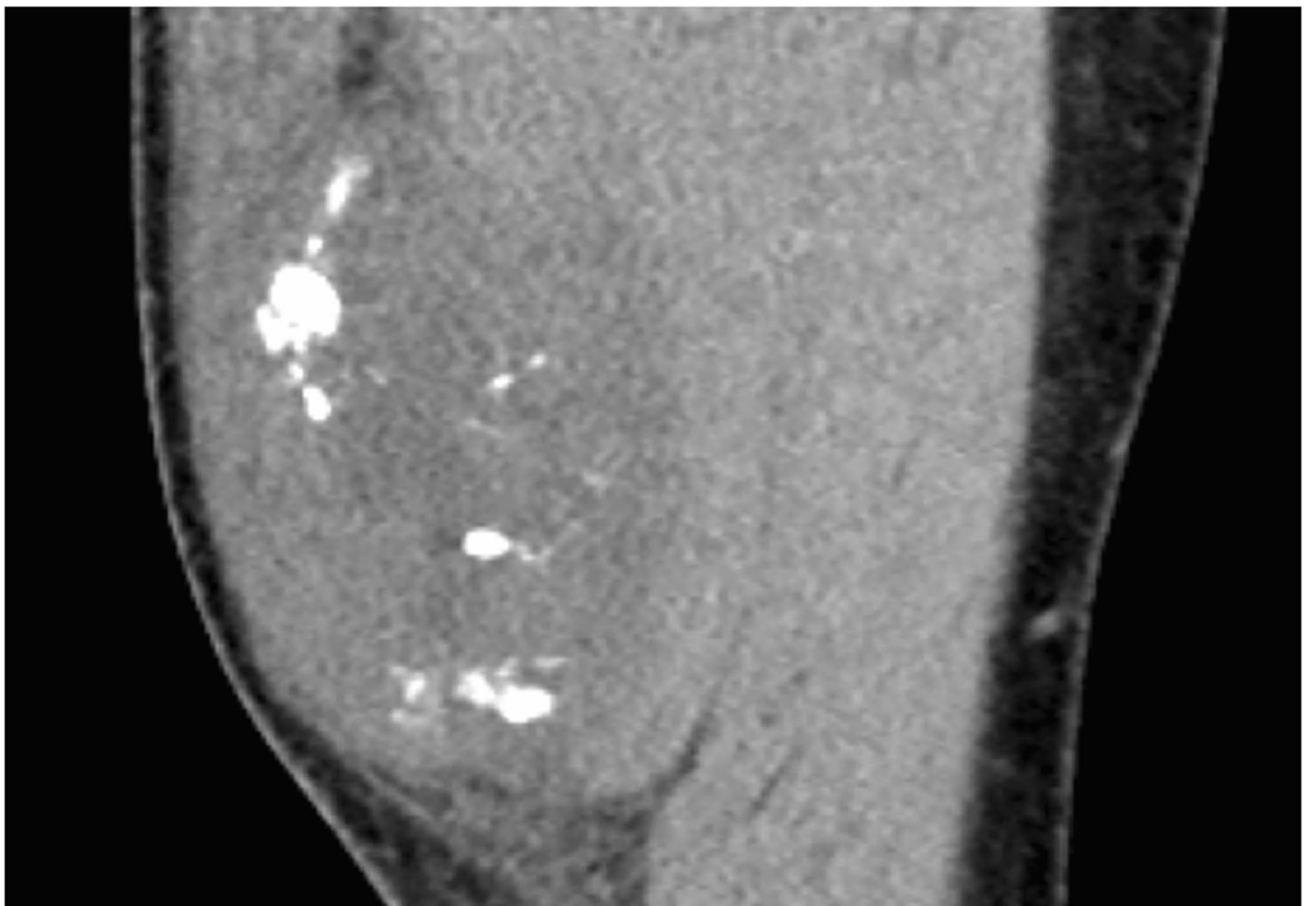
Coronal CT MPR of the right thigh
